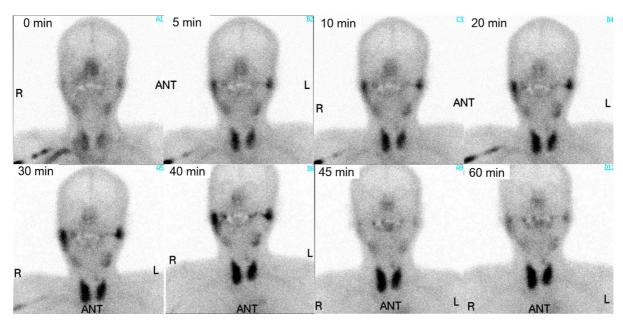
^{99m}Tc-pertechnetate scintigraphy shows satisfactory tracer accumulation in the bilateral parotid glands, but decreased accumulation in the submandibular glands, before lemon juice stimulation. Tracer washout at 40 minutes after lemon juice stimulation was identified in the parotid glands. *ANT*, anterior.
